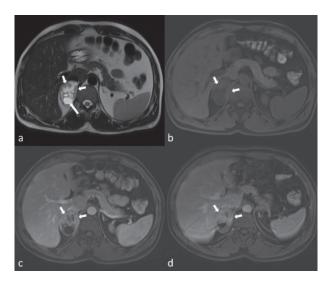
(a) The lesion was heterogeneously hyperintense on axial T2-weighted MR image and contained cystic (long arrow) and solid components (short arrows). On dynamic contrast enhanced MRI examination (b) precontrast, (c) arterial phase, (d) delayed phase), contrast enhancement was detected in solid portions of the lesion (arrows) and wash-out was not detected in late phase images (arrows).
